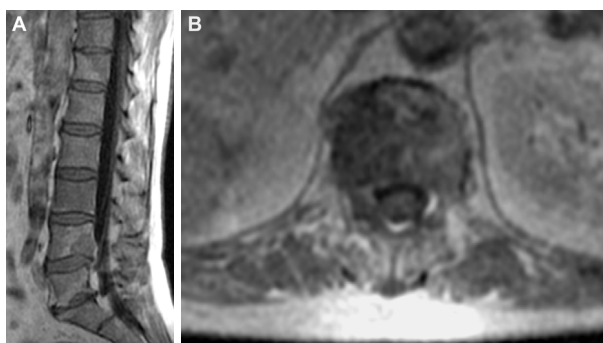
(A) Lumbar spine MRI: Post-contrast T1-weighted sequence – homogeneous enhancement of vertebral lesions at a patient with MH; (B) Lumbar spine MRI: Post-contrast T1-weighted sequence – heterogeneous enhancement of vertebral metastasis. MRI: Magnetic resonance imaging; MH: Malignant hemopathy.
